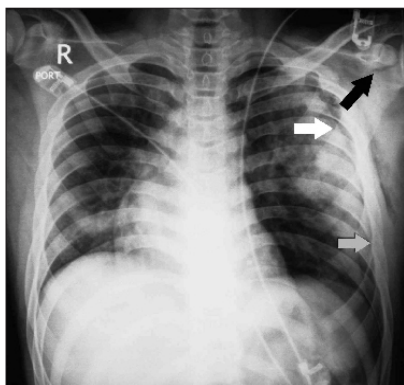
Chest x-ray on arrival to the emergency showing left glenoid (black arrow) and left rib 4, 5, 6, and 7 fractures (gray arrow points to the fracture in rib number 7) as well as left lung contusion and pneumothorax (white arrow).
